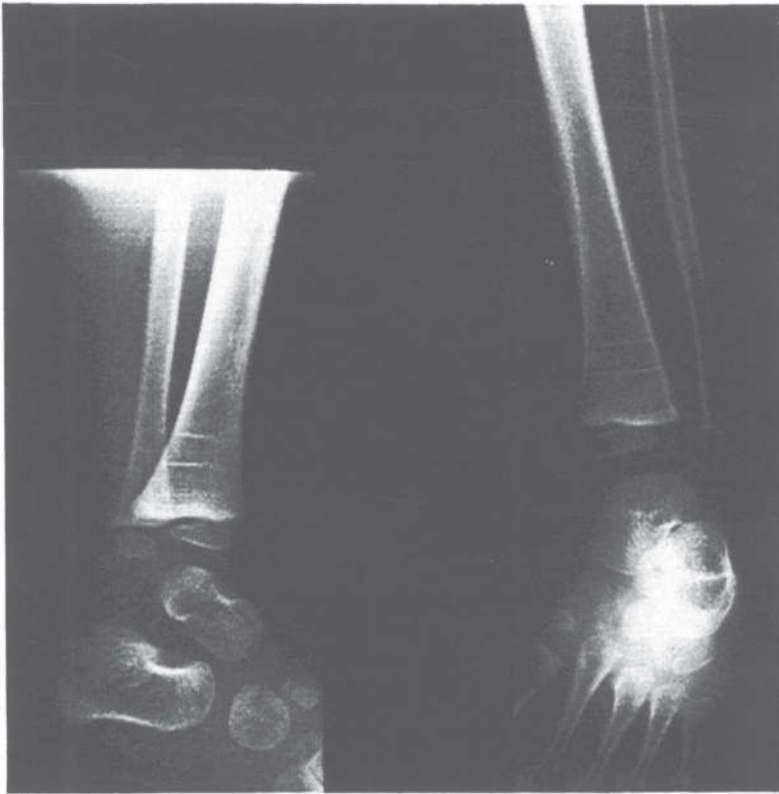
X-ray photograph showing arrested bone growth lines
